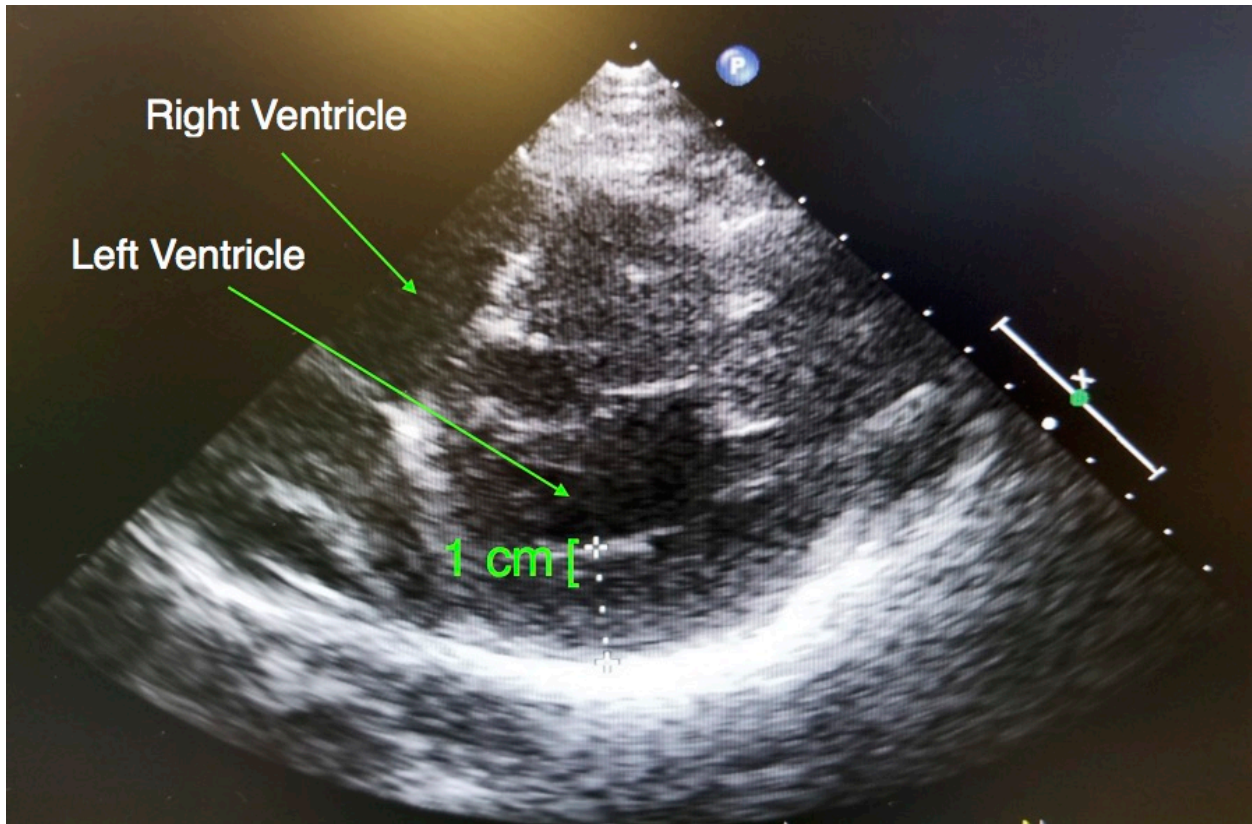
Transthoracic echocardiogram image of the parasternal short axis view taken after CSE placement. Left ventricular wall was measured and was noted to be > 30mm in thickness
